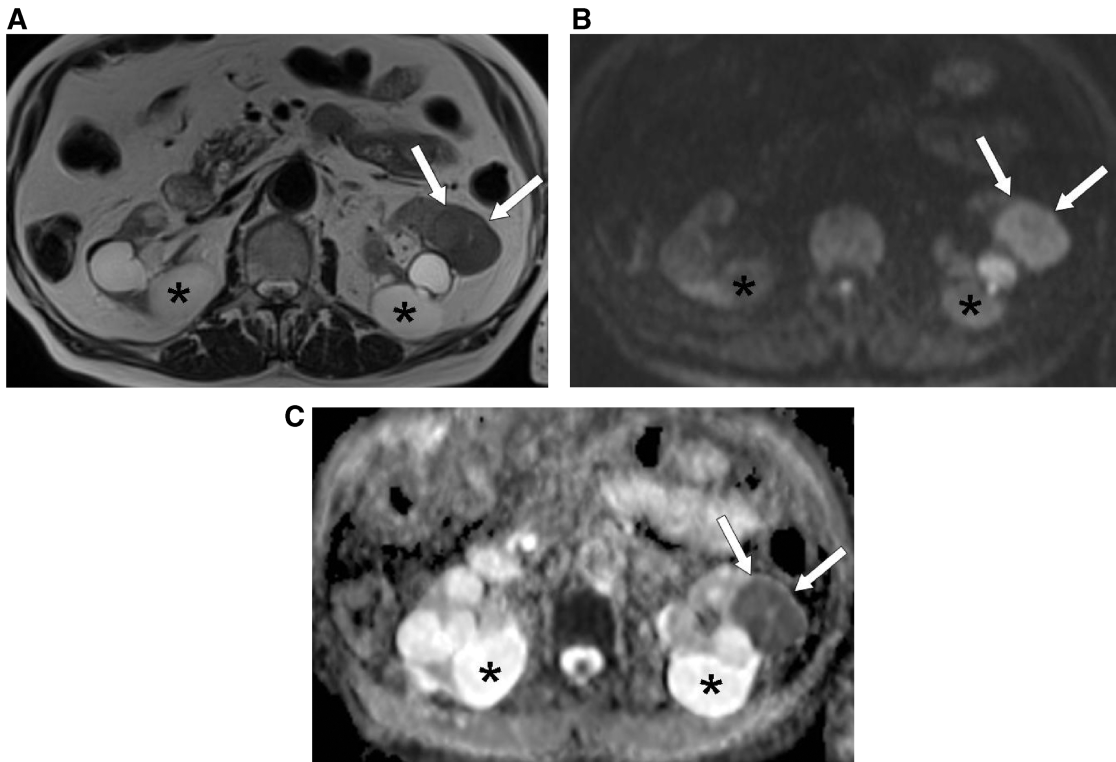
MRI (at 1.5 T) of a 79-year-old patient with an RCC in the left kidney (arrows). (A) Axial T2-weighted MR image shows intermediate signal intensity of the RCC, which is comparable with that of normal parenchyma, and high signal intensity for the multiple bilateral simple cysts (asterisk). (B) DW-MR image at a b value of 900 s/mm^2 shows high signal intensity of the RCC (arrows) and low signal intensity of the simple cysts (asterisk). (C) In the ADC map the RCC is clearly visualized as an area of impeded diffusion (arrows), represented by colour shades of dark grey, in contrast with the normal parenchyma of the left kidney and with the simple cysts (asterisk), which return colour shades of intermediate and light grey, respectively.
